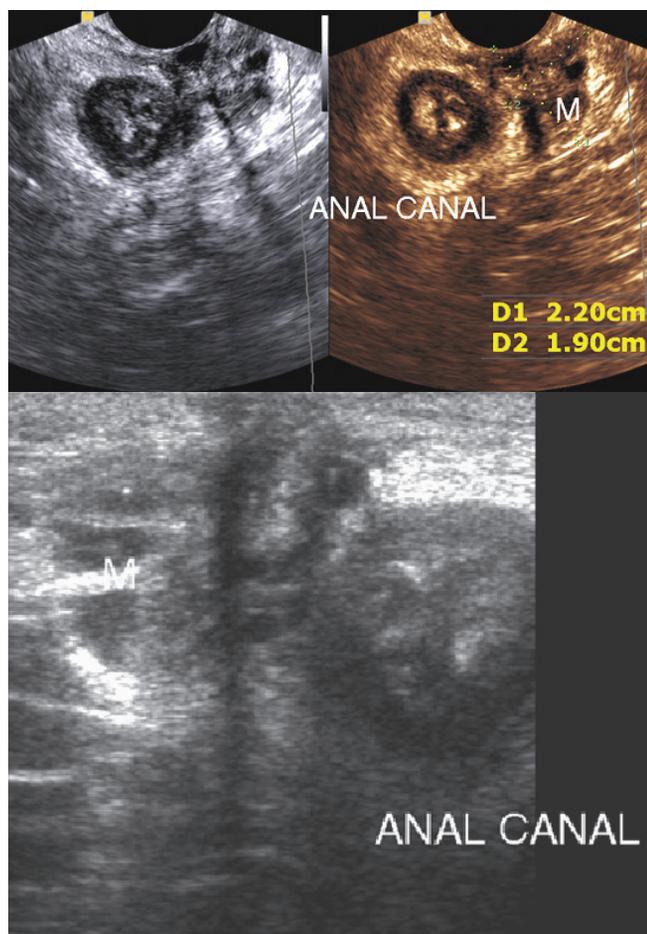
Transvaginal ultrasound of perianal endometrioma of mixed cystic and solid pattern (M), seen partially infiltrating the anal external sphincter
